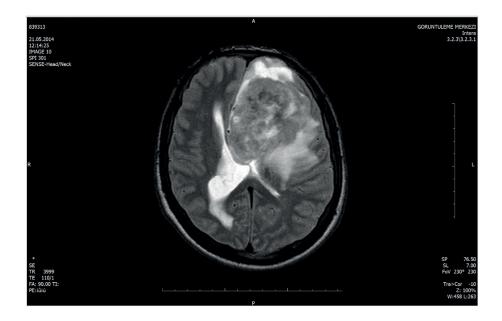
Preoperative cranial T2 axial MRI.
